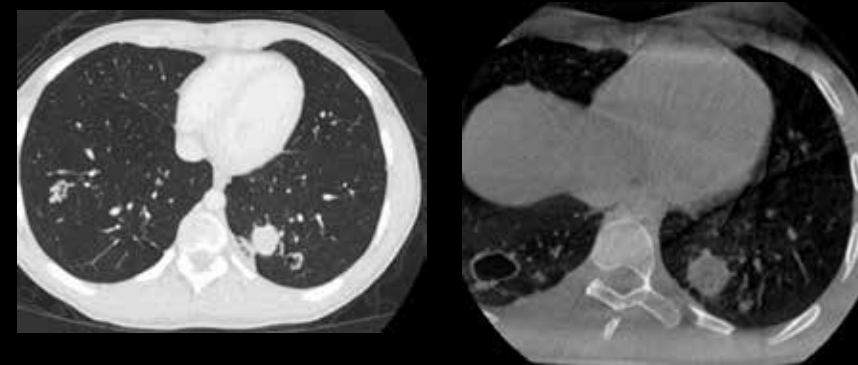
Pre-operative CT (left) and intra-operative cone beam CT (right) showing the lower left lobe nodule
